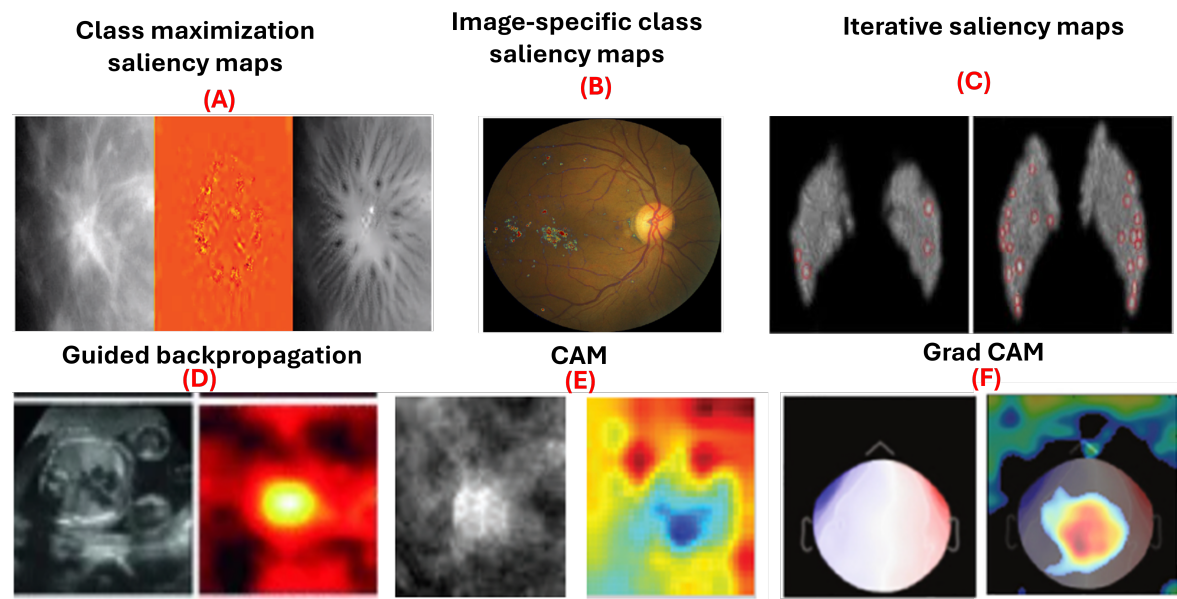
Examples of gradient-based attribution methods for model interpretability. (A) Class maximization visualization of malignant and benign breast masses on mammograms [9]. (B) Integrated gradients visualizing evidence of diabetic retinopathy on retinal fundus images [45]. (C) Visualization of malignant and benign breast masses [9]. (D) Guided backpropagation applied to ultrasound images for fetal heartbeat localization [4]. (E) Differentiation between benign and malignant breast masses in mammograms [6]. (F) Grad-CAM visualizations identifying discriminative regions in magnetoencephalography images for detecting eye-blink artifacts [52].
